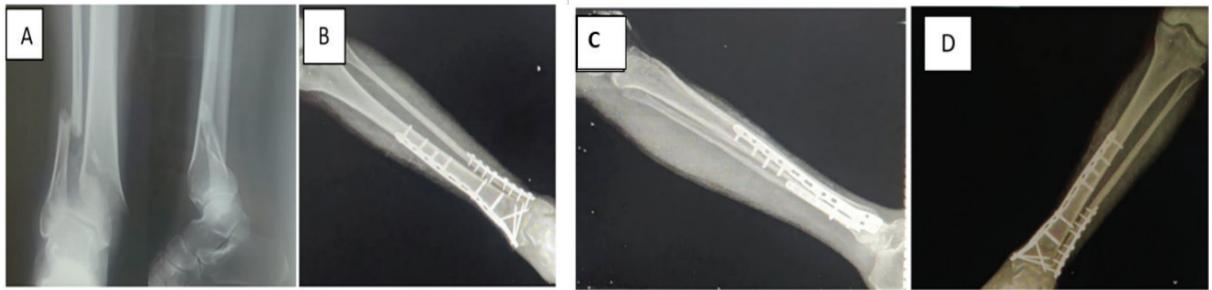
Preoperative Xray (A), Immediate Postoperative X-rays Anteroposterior and Lateral (B and C) and at the Time of 6 Months Follow Up (D)
